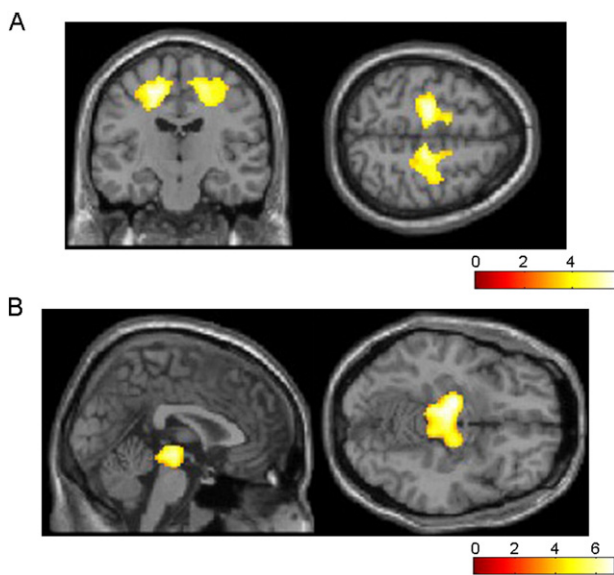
Regions of WM reduction in CBS (A) and RS (B) patients relative to controls. The most significant areas of atrophy observed in 9 CBS patients compared to 16 controls are the bilateral frontal subcortical WM including the left dominant bilateral precentral and right cingulate gyrus (A). The most significant areas of atrophy observed in 17 RS patients compared to 16 controls are in the bilateral midbrain (B). Significance maps of WM reduction in CBS and RS patients are superimposed on a T1-weighted brain MRI template image in the Montreal Neurological Institute space. The color bar represents the t value.
